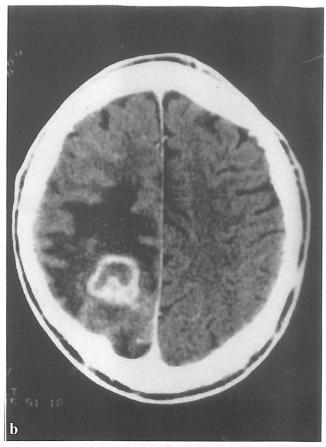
(a-b): Primary CNS lymphoma; axial pre(a) and post (b) contrast CT in a patient shows a single ring enhancing lesion in supraventicular subcortical tissue with marked edema.
